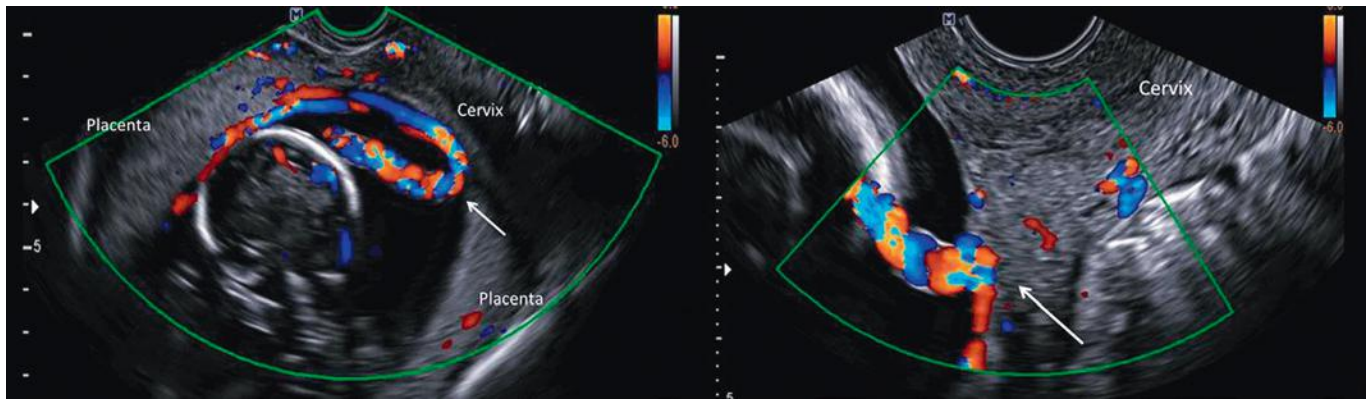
Transvaginal sonography with color Doppler flow imaging demonstrates vasa previa, with fetal vessels crossing the cervix. The cord insertion is velamentous (*arrow*), in close proximity to the internal cervical os.
